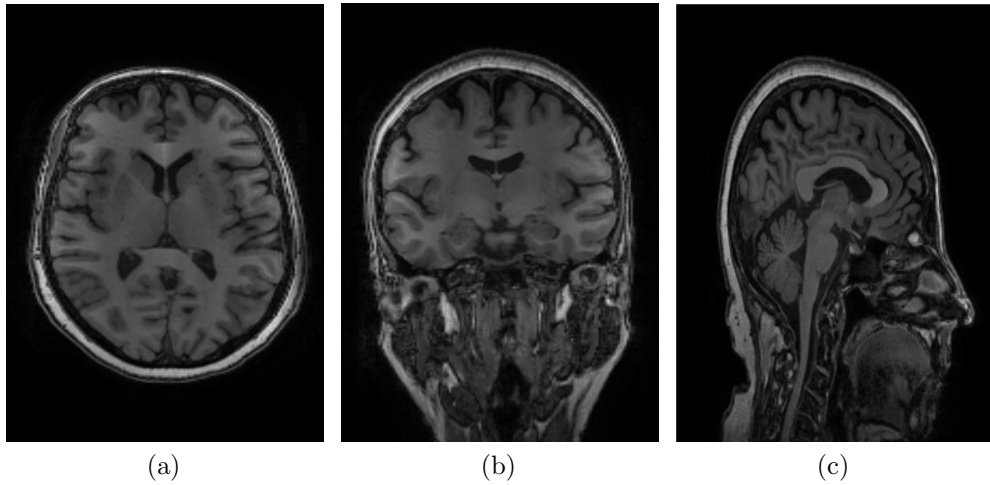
Selected original MRI T1 before preprocessing in three different planes: (a) Axial, (b) Coronal, (c) Sagittal.
